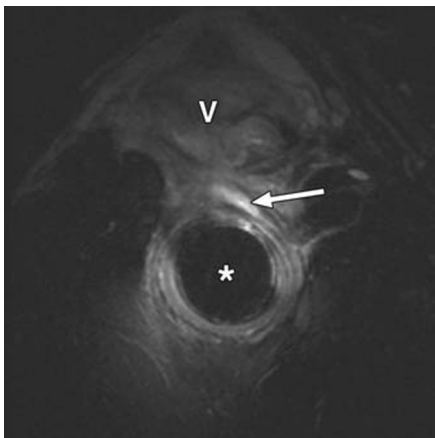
29-year-old woman with anterior anal and perianal pain 2.5 years after surgery for rectovaginal fistula. No abnormalities were found at examination under general anesthesia. Axial T2-weighted MR image with fat saturation shows linear structure of high signal intensity (arrow), which suggests presence of active fistula. Lesion extends from anus to perineum. No extension of fistula to vagina (V) is evident; finding was confirmed at surgery. Fistula is in contact with internal anal sphincter, and local thinning of internal anal sphincter at site of contact is evident. Asterisk indicates endoluminal coil in anal canal.
